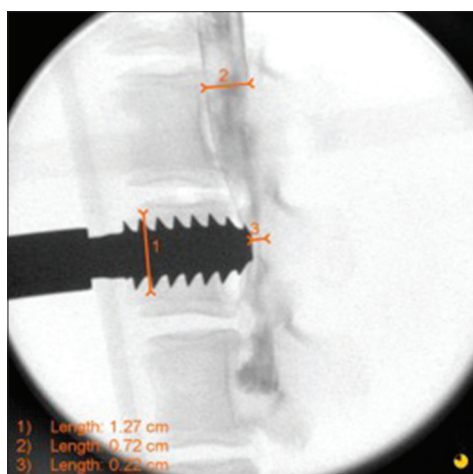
Example of a lateral fluoroscopic/computed tomography image of a spinal segment when the dynamic hip screw reached approximately 70% of spinal cord compression. (1) An example measurement of the dynamic hip screw width, (2) width of the noncompressed spinal cord, and (3) width of the compressed spinal cord. Two lateral computed tomography images were taken during each experiment: the first at timestamp 0 (opening pressure), and a final one following the last compression. Pre- and post-images were used to correlate pressure response to graded degrees of canal compromise
